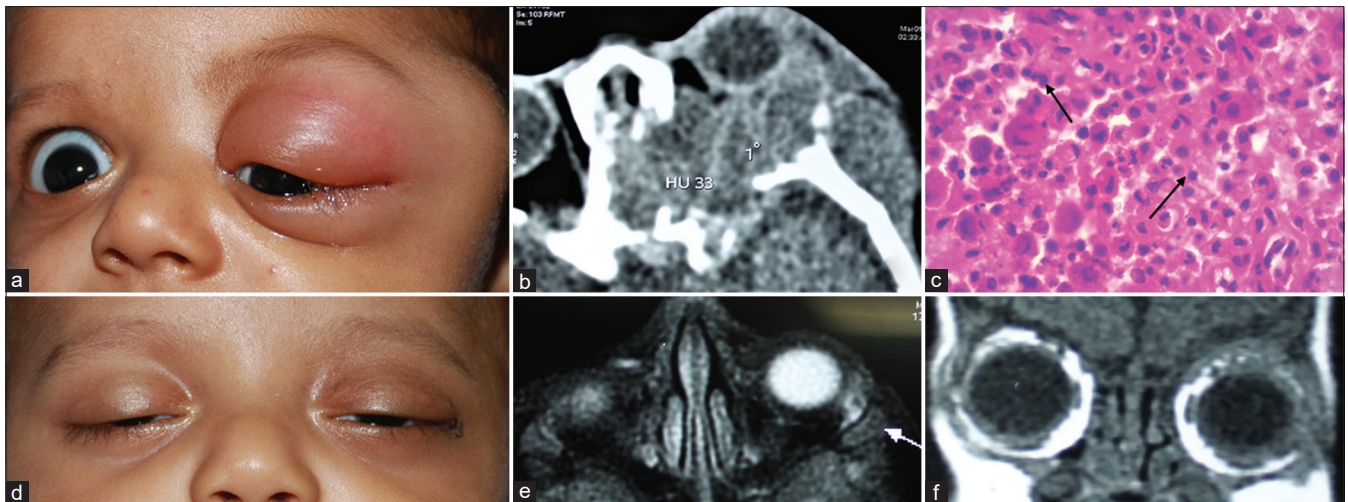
(a) A 2 years old boy presented with a left upper eyelid swelling resulting in mechanical ptosis. Palpation revealed a firm mass in the supero-temporal quadrant. (b) CT scans, axial view showing punched out a lytic lesion on the roof of the left orbit with soft-tissue mass (white arrow). (c) Microphotograph showing numerous multinucleated giant cells, Langerhans cells with characteristic membrane grooving and eosinophils (black arrows) (d) Clinical photograph showing resolution of eyelid swelling following surgery and systemic chemotherapy. (e and f) MRI images axial and coronal cuts showing near complete resolution of the mass
